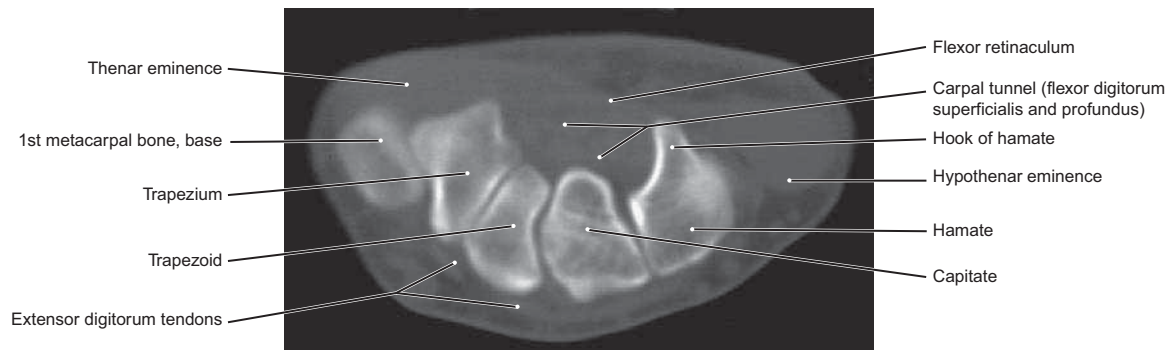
CT of the Right Wrist
